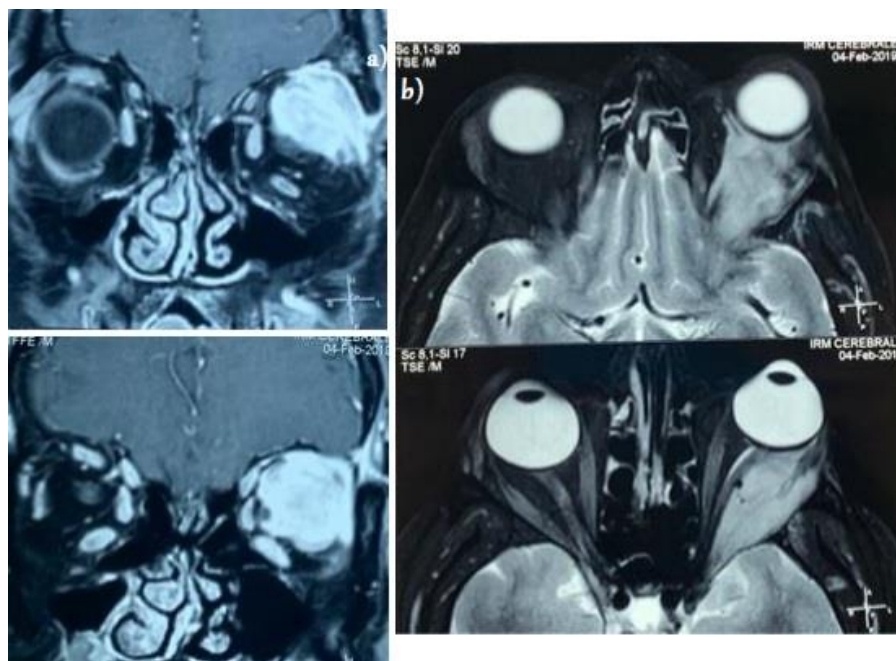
a) Coronal b) Axial MR images showing a left lacrimal gland tumor with a local invasion.
